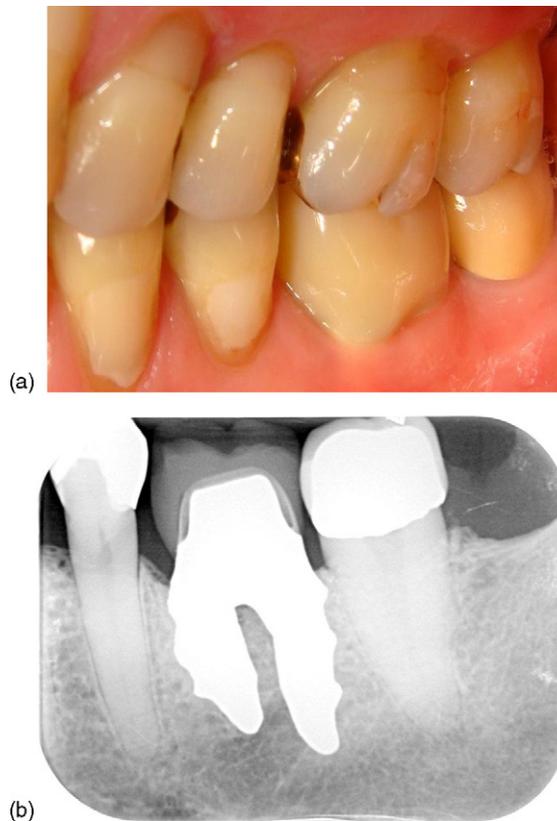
(a) Two year follow-up with zirconia implant in place with definite prosthetic restoration. (b) X-ray at 2 year follow-up.
